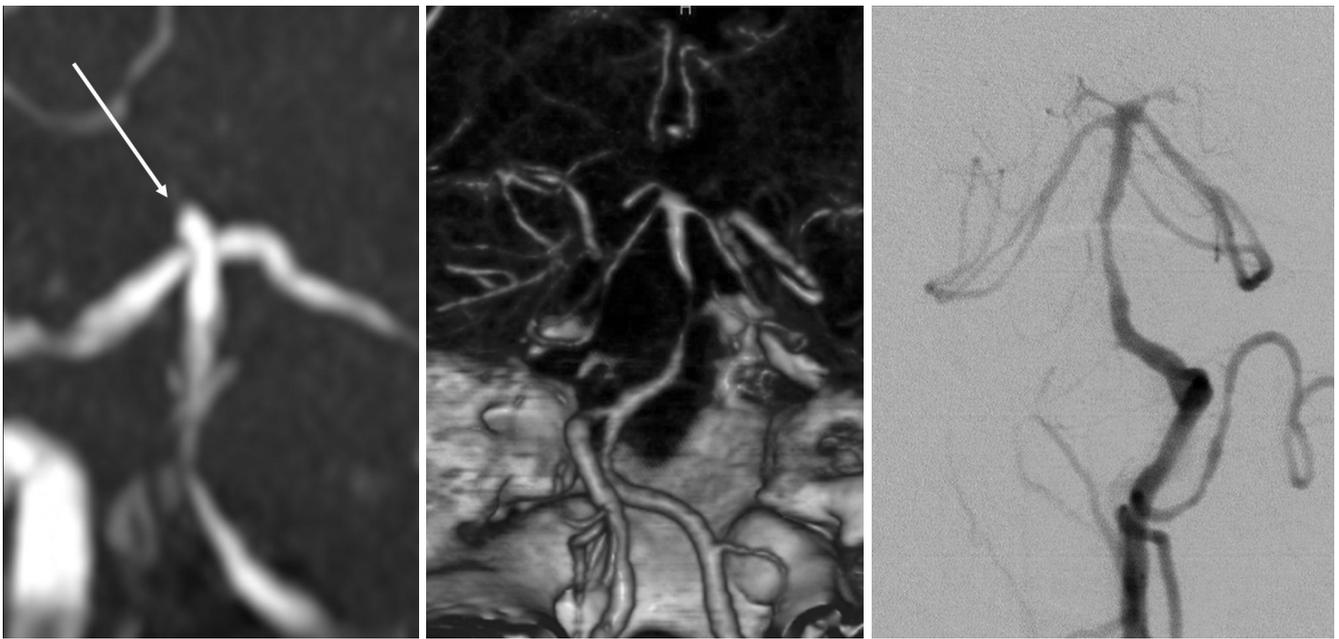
False-positive aneurysm of the top of the basilar artery in a 51-year-old man. A saccular aneurysm (arrow) is seen at the top of the basilar artery on Time-of-flight MR angiography (A). CT angiography (B) demonstrates junctional dilatation at that region. Right vertebral angiogram (C) also shows junctional dilatation.
